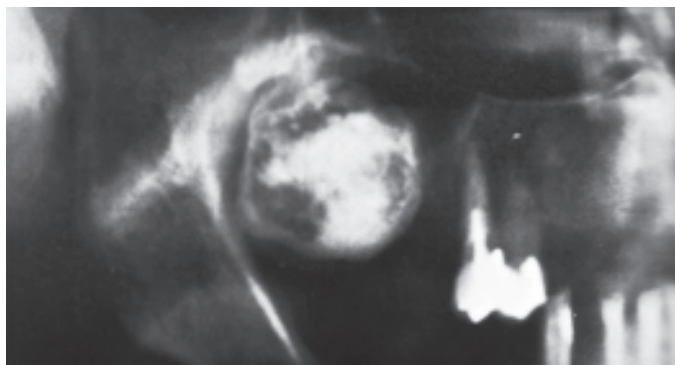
Radiographic appearance of multilocular intraosseous radiolucencies of osteoma
